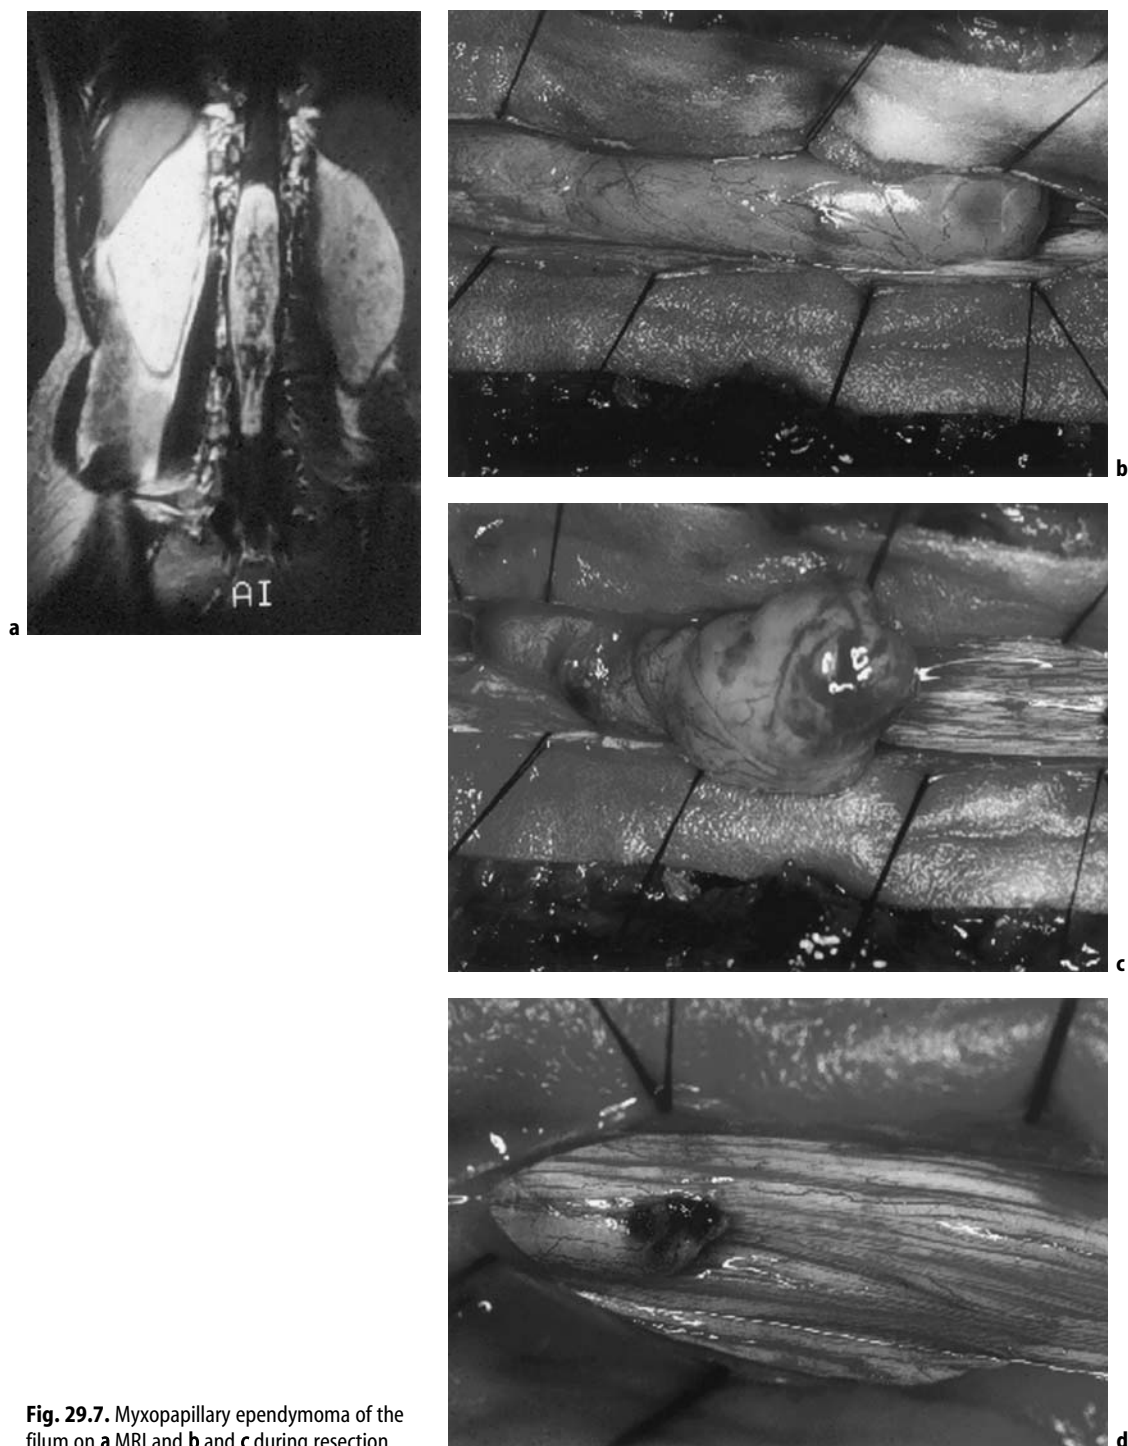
Myxopapillary ependymoma of the filum on a MRI and b and c during resection.
